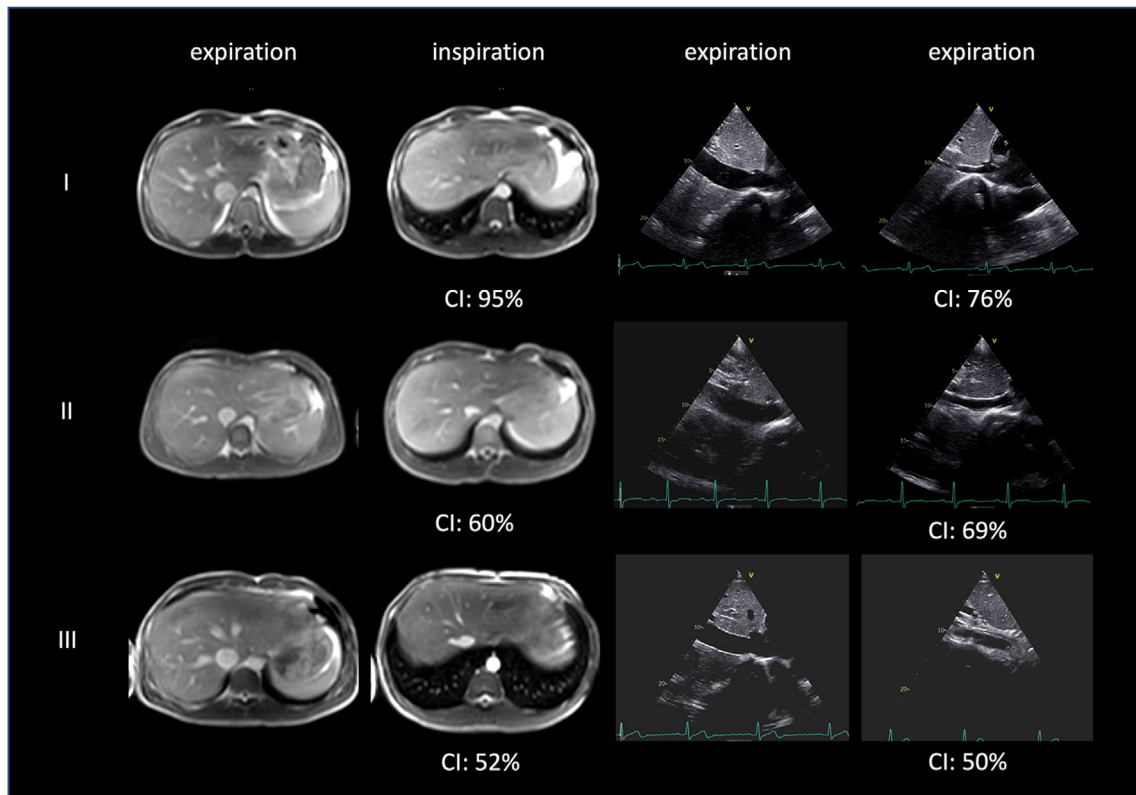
Expiratory and inspiratory IVC at MRI and TTE in three subjects. In each case, CI for each modality is provided. For MRI, the TTE-like diameter for CI calculation was used.
